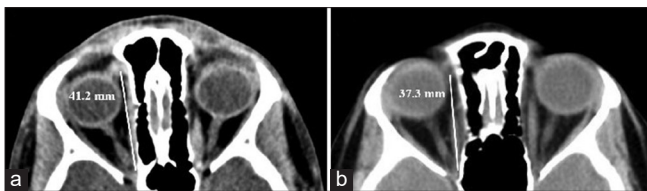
Axial computed tomography scan of the orbit, demonstrating the distance between annulus of Zinn and trochlea in our patient (a) and one representative age- and sex-matched control patient (b)
